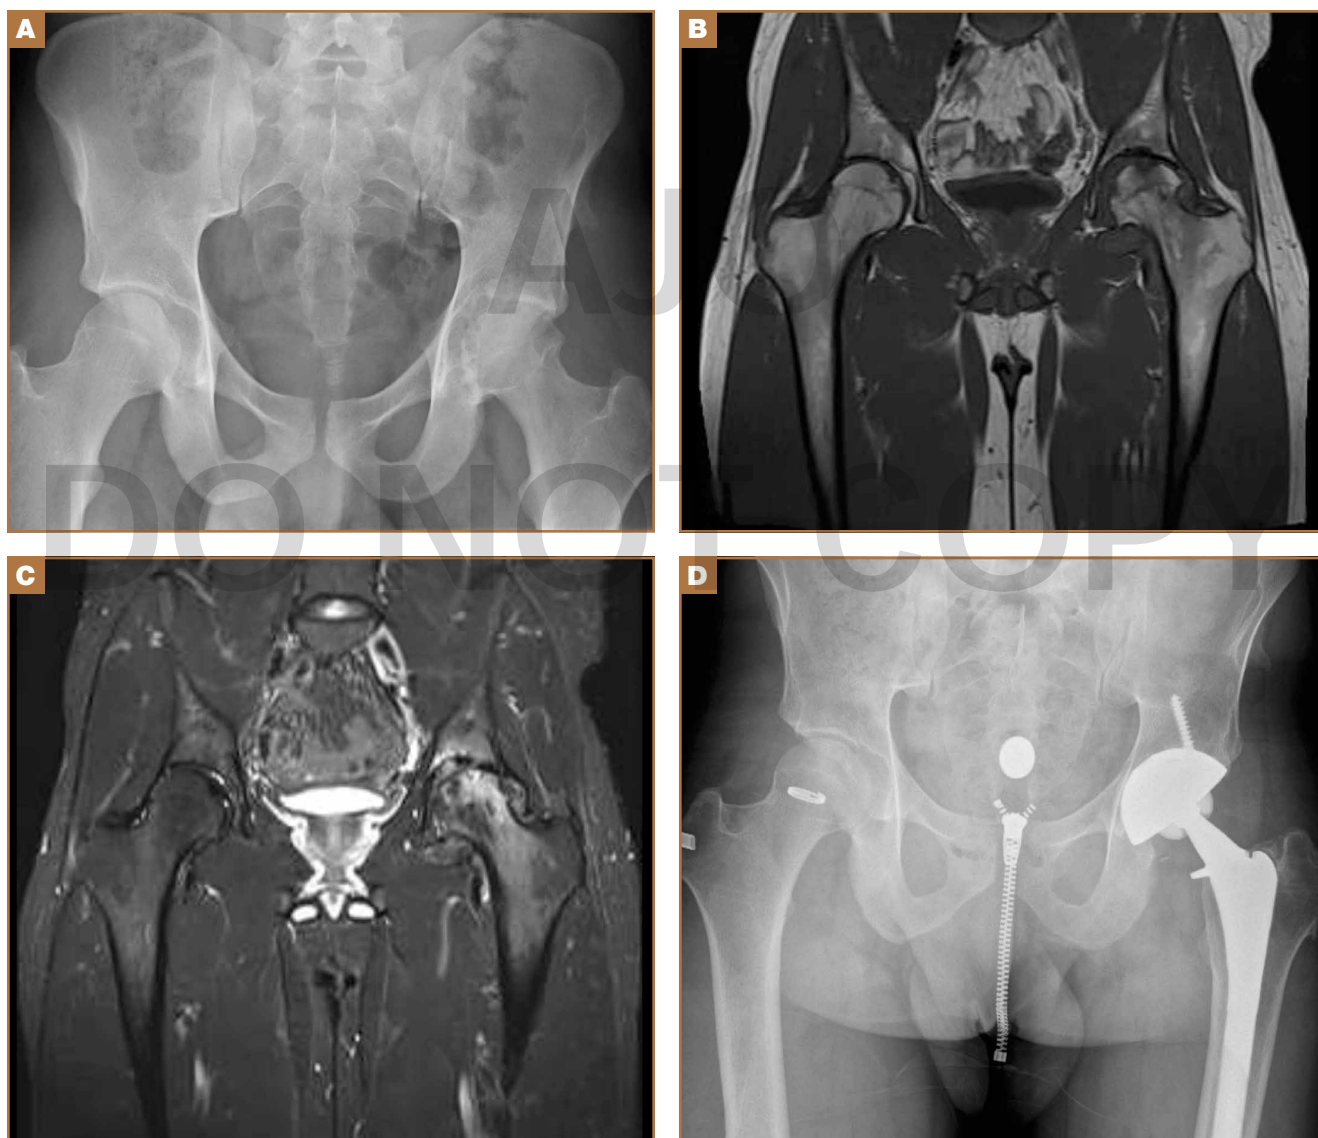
(A) Anteroposterior radiograph of pelvis of 22-year-old man shows advanced joint space narrowing and cortical erosions in femoral head and acetabulum of left hip. Magnetic resonance imaging shows characteristic synovial process with low-signal intensity in both (B) T1-weighted and (C) T2-weighted sequences. (D) Patient underwent total hip arthroplasty.
